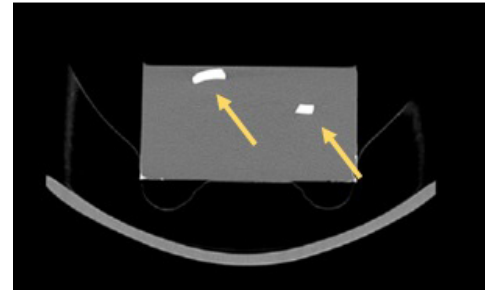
CT of the model. Glass splinters.
